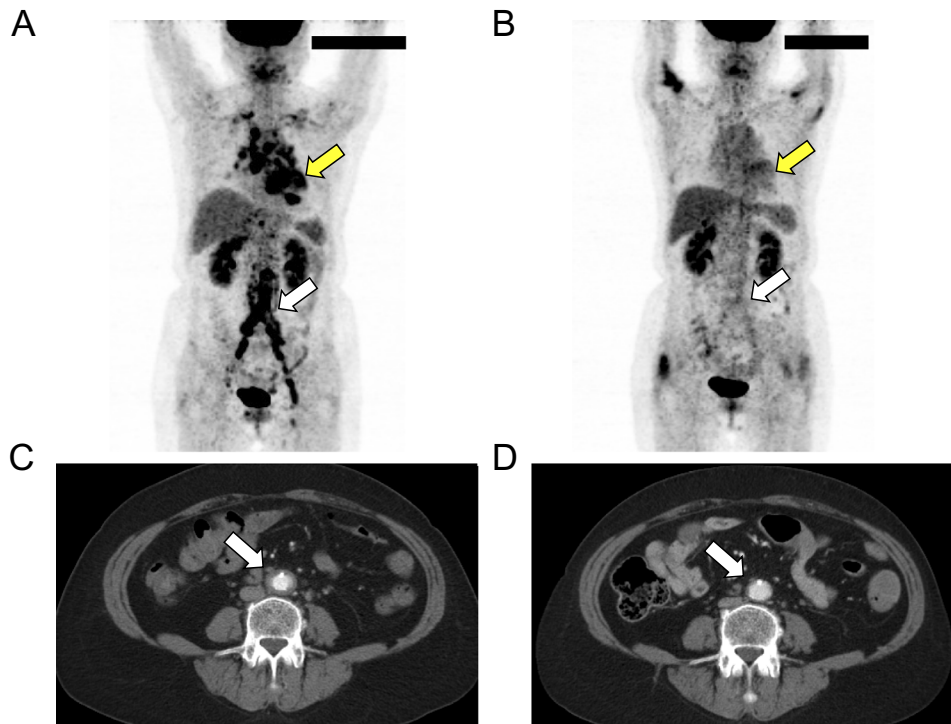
FDG-PET and contrast-enhanced CT angiography before (A, C) and after (B, D) steroid therapy. A: FDG-PET image (three-dimensional maximum intensity projection) depicted the focal FDG accumulation in the basal anteroseptal to the lateral wall of the left ventricle (yellow arrow). The extracardiac FDG uptake was also evident along the large vessels from the infra-renal aorta to the bilateral iliac arteries (white arrow) as well as in the hilar and mediastinal lymph nodes and the small nodular lesions of the bilateral upper lobe. B: After tapering prednisolone from 65 mg/day to 30 mg/day over 8 weeks, the abnormal accumulation of FDG was markedly diminished in both the heart (yellow arrow) and extracardiac lesions including large vessels (white arrow). C: Contrast-enhanced CT of the sagittal section of distal abdominal aorta just above the bifurcation, showing the vessel wall thickening and slight narrowing of the aortic lumen (white arrow). D: Contrast-enhanced CT showed recovery of the wall thickness and lumen narrowing compared with (C) (white arrow).
